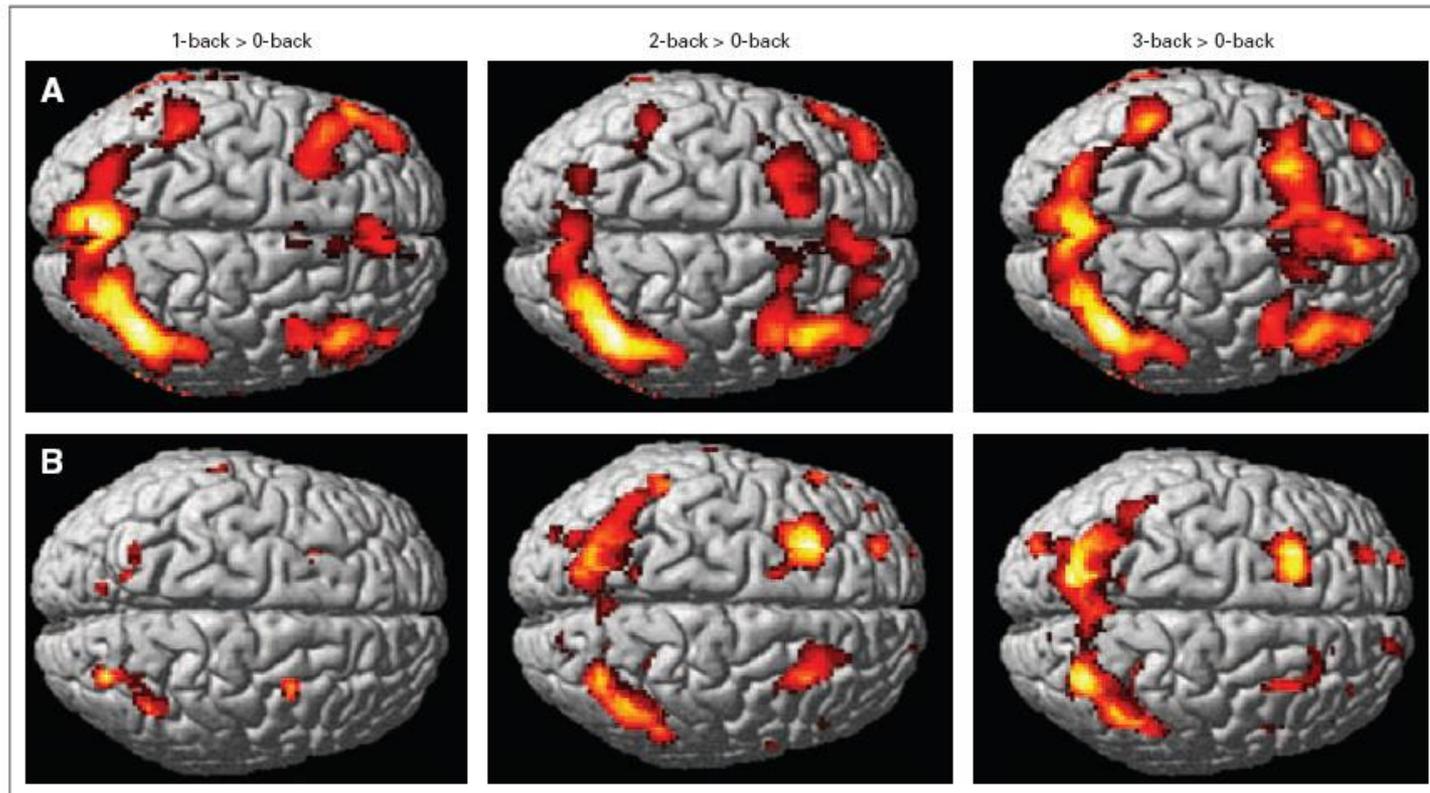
Functional magnetic resonance images of 60-year-old identical twins during a working memory task with incrementally increasing levels of difficulty (left to right). Colored regions denote increased brain activation during working memory relative to a simple vigilance task. (A) Twin treated with chemotherapy; (B) twin who did not receive chemotherapy. Note the expanded spatial extent of cortical activation in the chemotherapy-treated twin.
